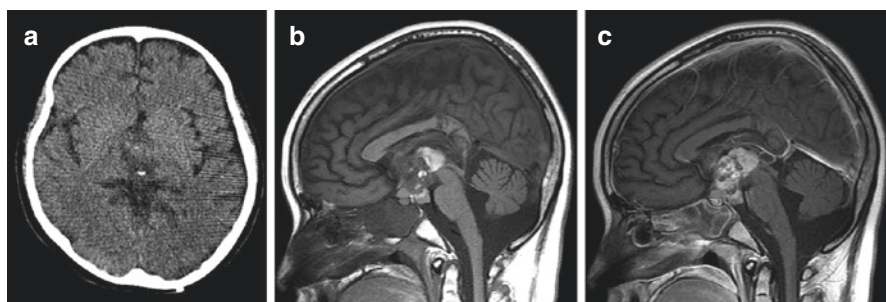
Immature teratoma arising from the suprasellar area in a 13-year-old boy. (a) CT scan shows a mass in the third ventricle with low attenuation. Minute dots of high attenuation are observed in the mass, indicating the presence of calcification. (b) Areas of high signal intensity are found in the tumor in a T1-weighted image which represent fatty tissues in the tumor. (c) The tumor is well enhanced in gadolinium-enhanced T1-weighted image
